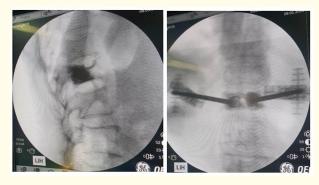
Intra op x-rays showing stentoplasty in collapsed vertebrae.
